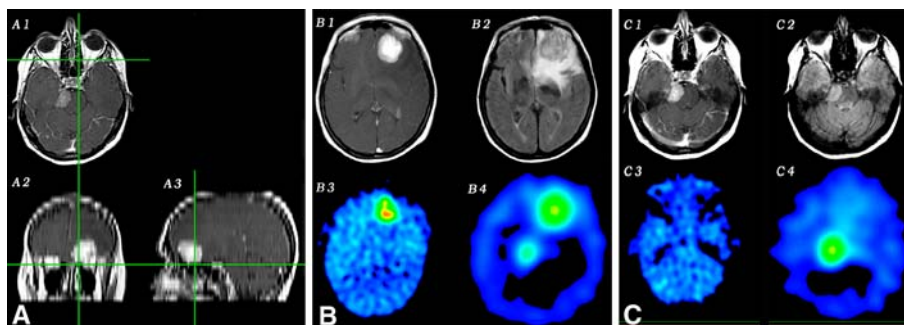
Panel A: Axial gadolinium enhanced MRI scan (A1) showing patient with a petro-clival meningioma with corresponding coronal (A2) and sagittal (A3) reconstruction's showing opposite frontal dural-based lesion. Panel B: Axial images of right frontal dural-based lesion (lymphoma on biopsy). (B1) T1 weighted image (T1WI) with diffuse enhancement of the tumor. (B2) Fluid attenuation and inversion recovery (FLAIR)
